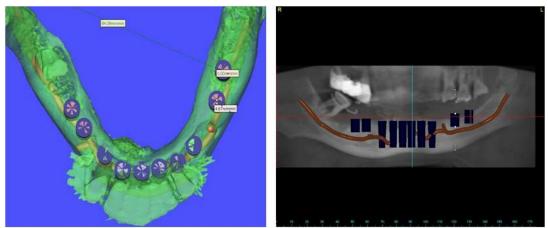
Pre-surgical implant planning using CT scan and Simplant program software
